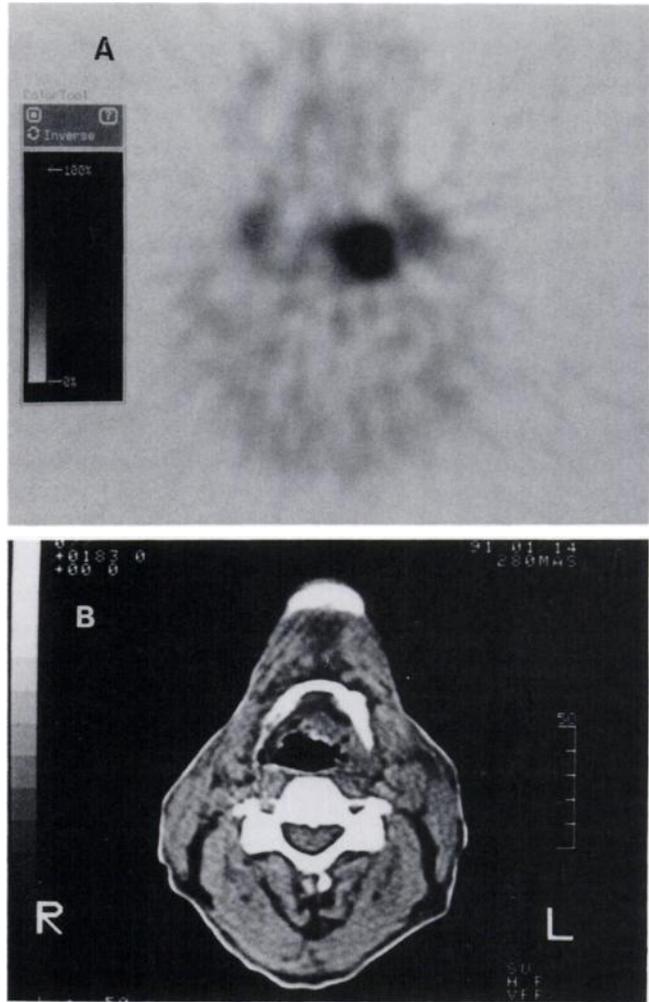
A ^{11}C -methionine PET image (A) and a computed tomography scan (B) taken from the same level in Patient 16.
